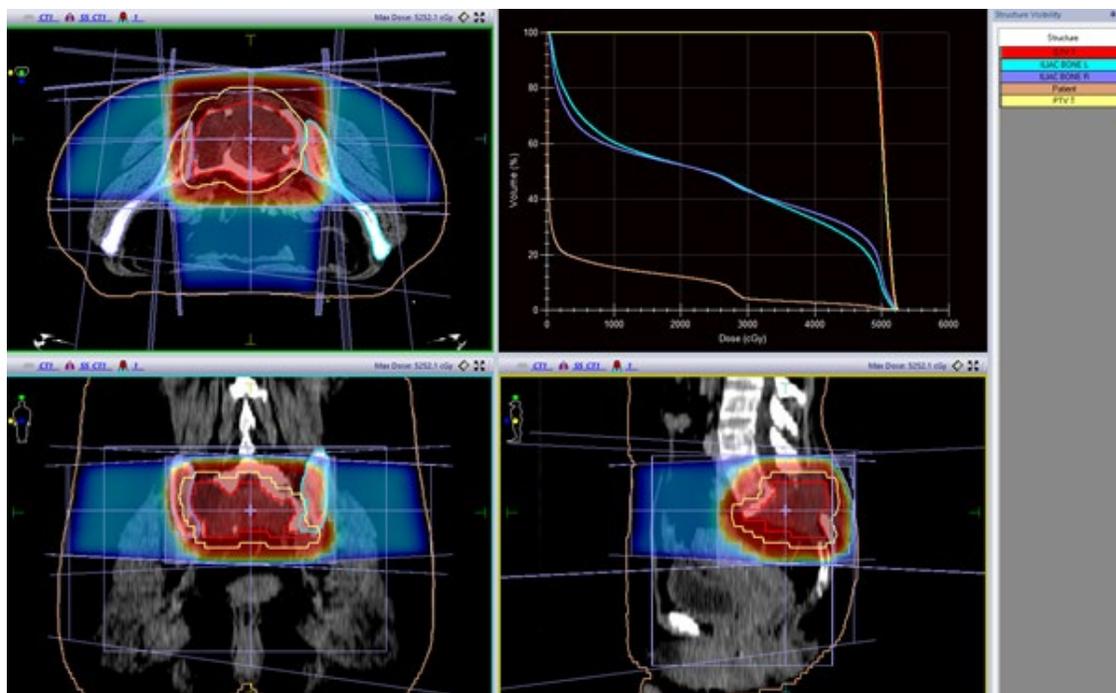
Planning review for 3D radiotherapy: computed tomography scan showing the target volumes: GTV in red, PTV-HR in yellow. (C) delivered dose to the region of high risk, was 50Gy Gy (95% isodose line in red). GTV, gross tumor volume, PTV, planning target volume; HR, high risk.
